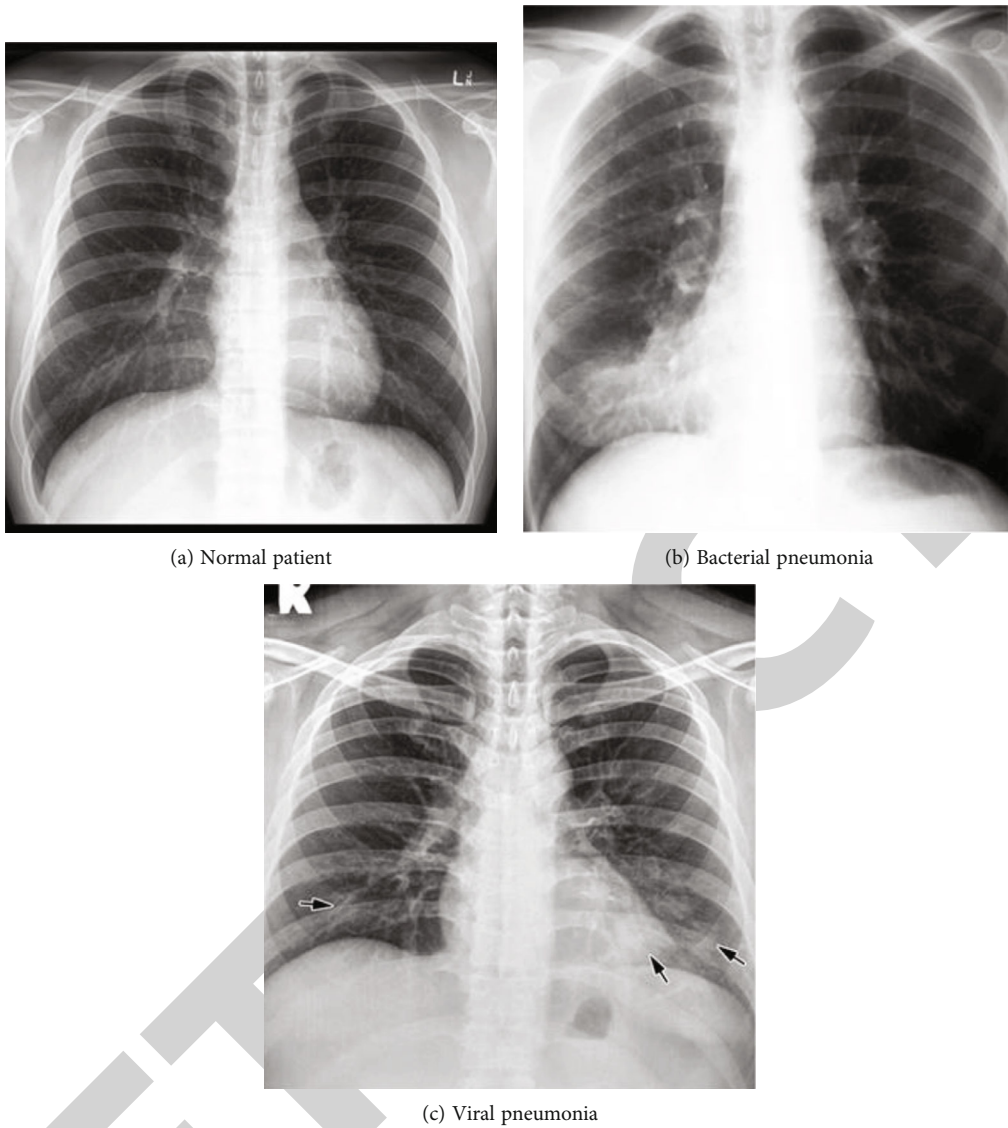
Chest radiographs: normal, viral pneumonia, and bacterial pneumonia.
